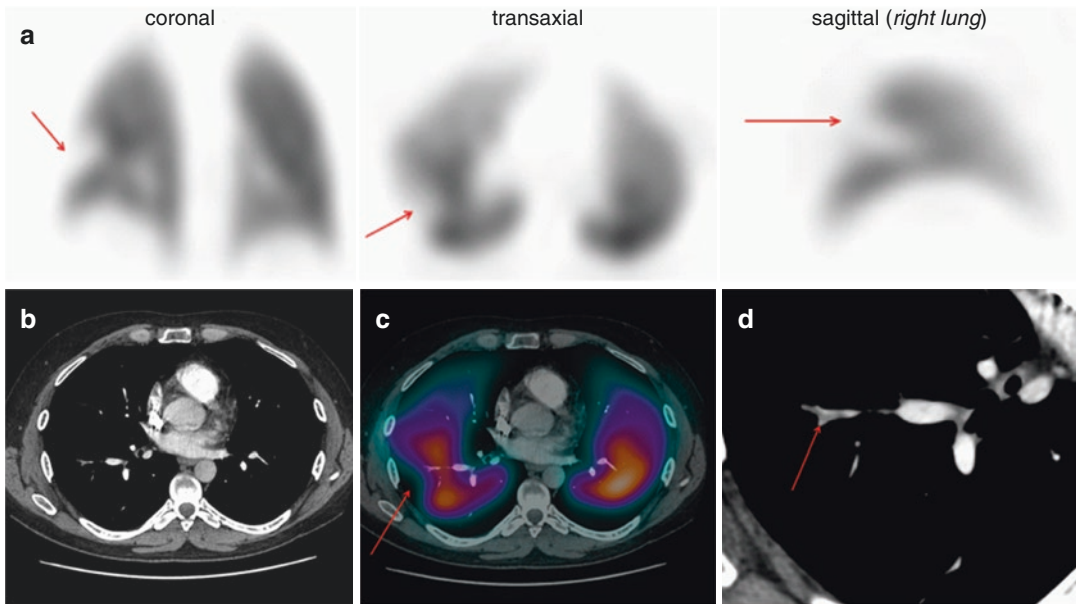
Images of a 43-year-old male with suspected PE. Representative perfusion images of the V/Q SPECT (a) show a (mismatched) perfusion defect in the superior segment of the right lower lobe (arrowed). A CTPA (b) was reported as normal. A fused image of the CTPA and perfusion SPECT (c) was generated, and following a more
